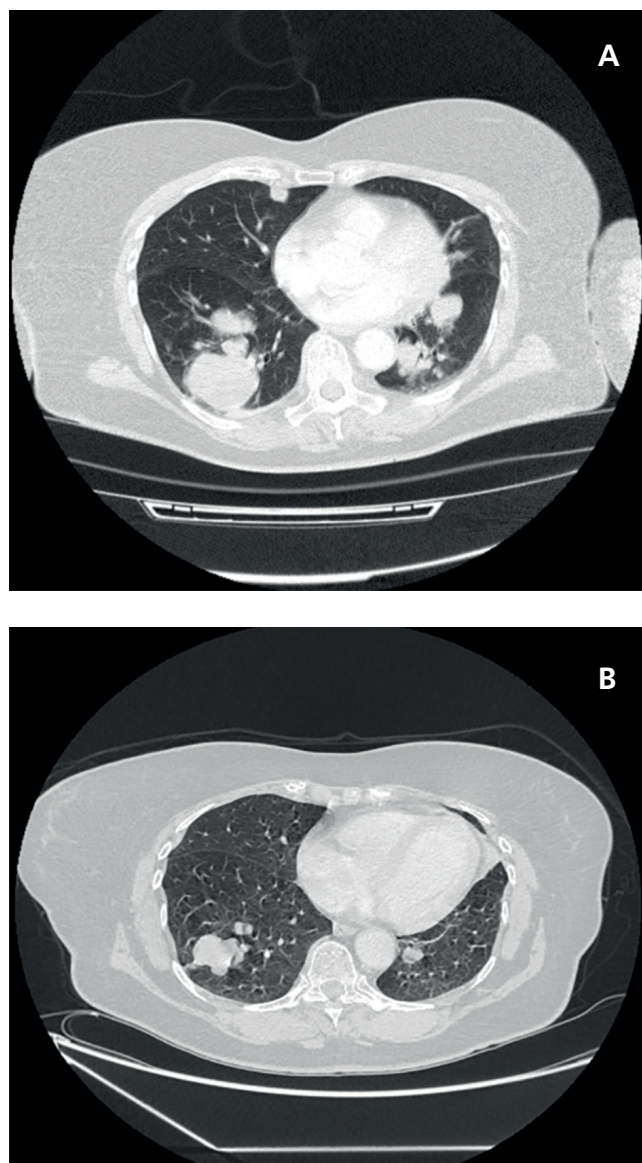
Computed tomography (CT) scan prior to initiating trabectedin (A) and after 4 treatment cycles (B) showing partial response according to RECIST criteria.
